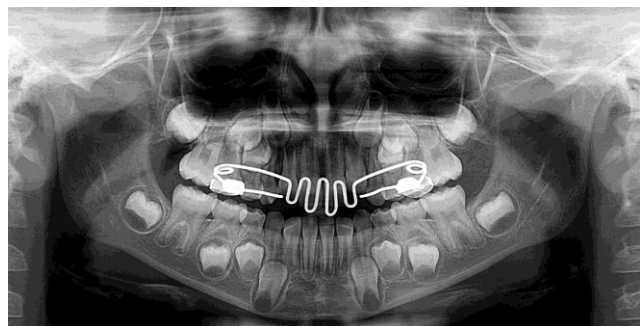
Final Panoramic Radiography (Source: Authors).
